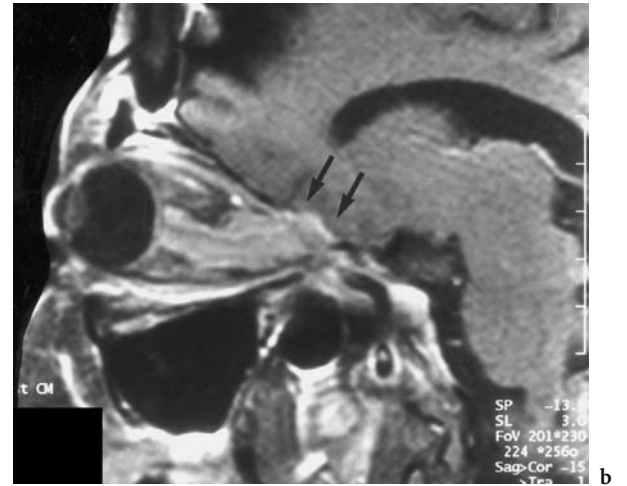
A 66-year-old woman with complete visual deficit of the right eye. Diagnosis: calcified right sphenoid wing meningioma. Axial CT: Nearly complete calcification of the tumor, arising from the clinoid process with retrograde infiltration of the entire optic nerve sheath through the optic canal into the orbit, and antegrade infiltration of the ipsilateral cavernous sinus. (With permission of MÜLLER-FORELL and LIEB 1995)
